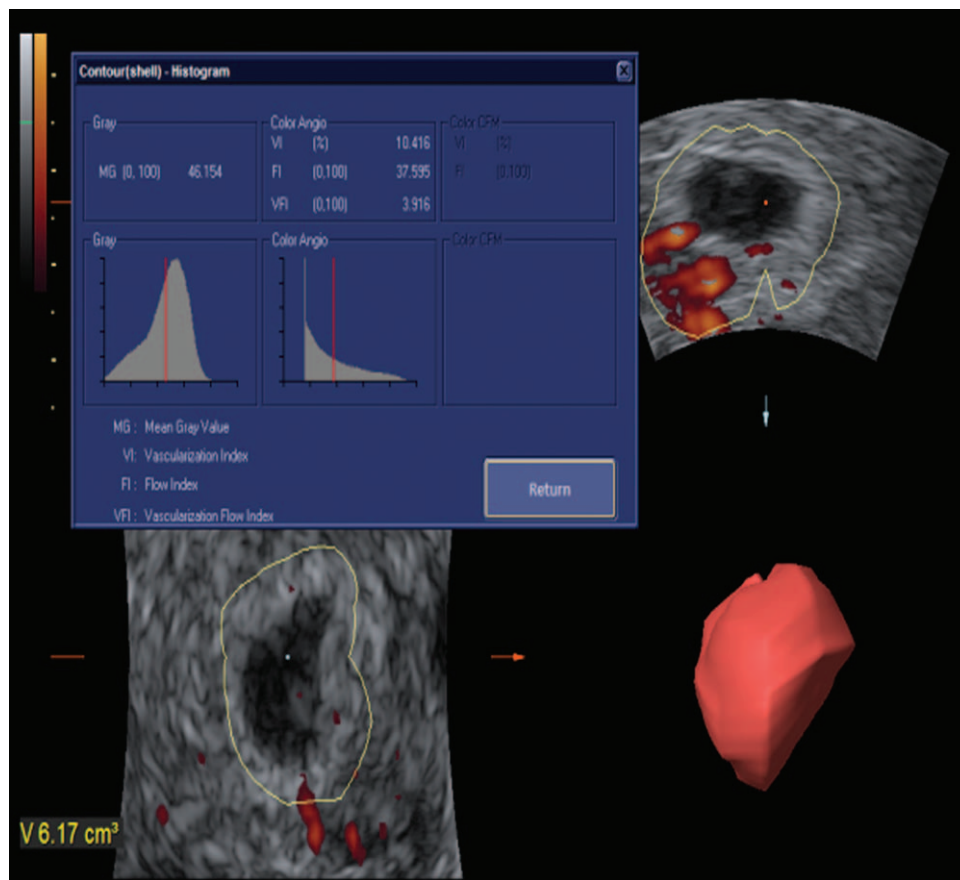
Three-dimensional power Doppler flow indices of cesarean scar pregnancy. The outer boundaries of the vascular "ring" were traced.
